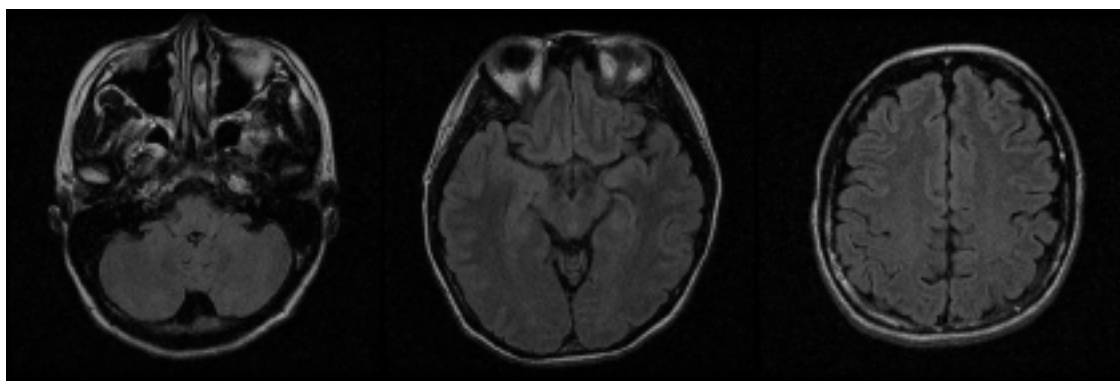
Brain MRI scans of Patient 2 four weeks after treatment with intravenous cyclophosphamide. T2 FLAIR imaging shows complete resolution of all high signal intensities compared with Figure 2A.
